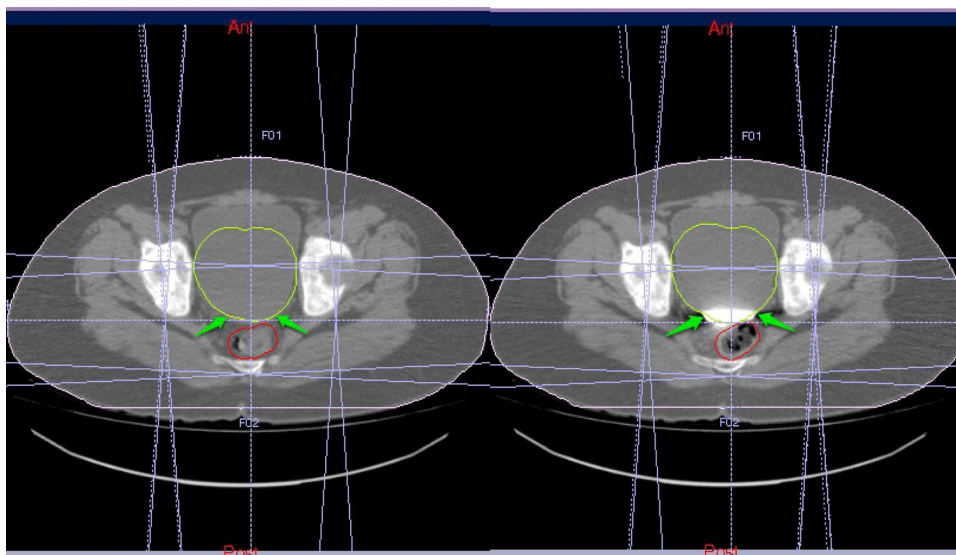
The pre-contrast CT (left) and the post-contrast CT (right).
